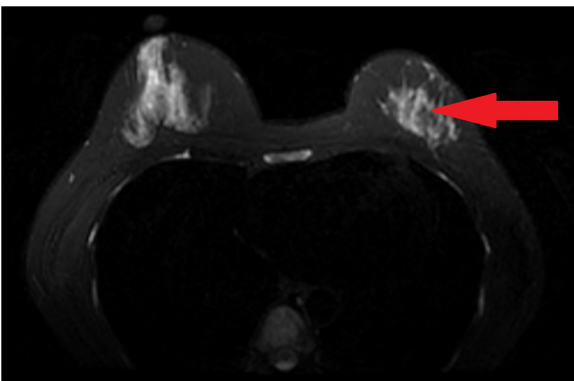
Follow-up breast MRI. The arrow indicates the location of the breast cancer lesion after treatment, which shows a marked reduction in size.
